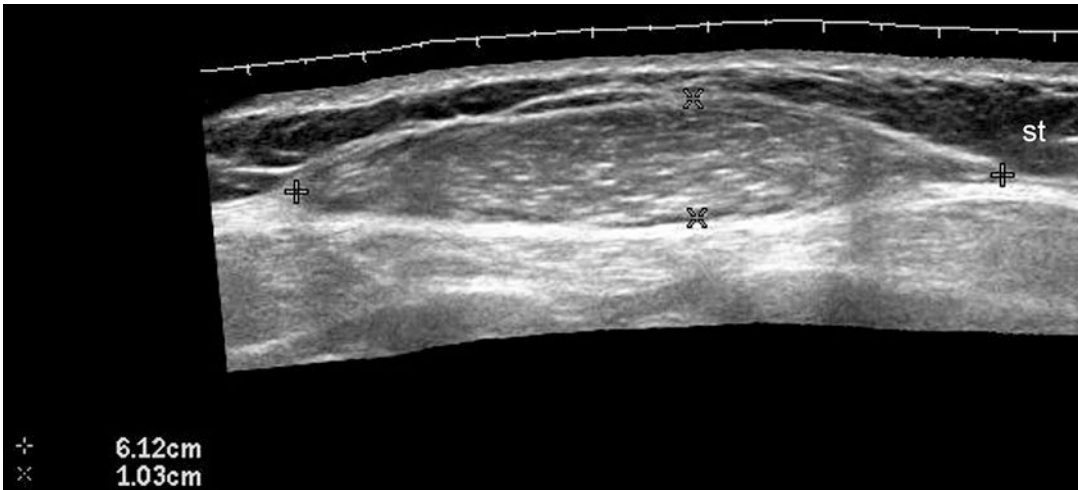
Lipoma. Grayscale ultrasound (transverse view, right flank of the abdominal wall) shows 6.12 cm long \times 1.03 cm wide, well-defined, oval-shaped hypoechoic mass (*) in the subcutaneous tissue
